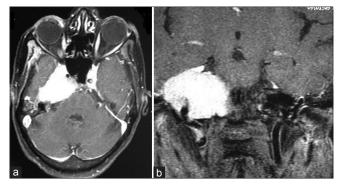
T1-weighted image with contrast (a) Axial (b) Coronal showing brilliantly enhancement of the lesion
